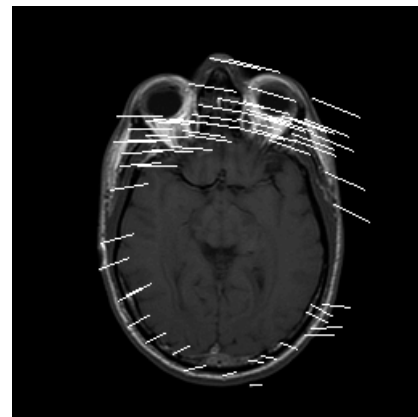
The translation vectors between matched patches shown relative to gold standard T1-weighted MRI slice
